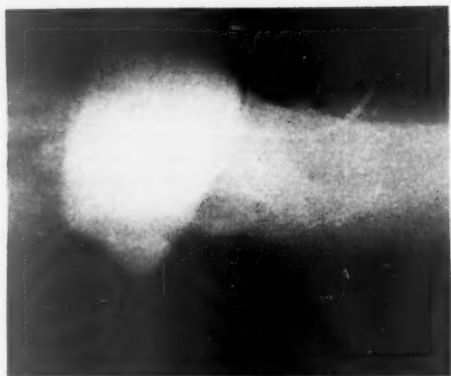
Radiograph of the bladder containing sodium iodide and a small volume of Myodil. The patient is supine.
